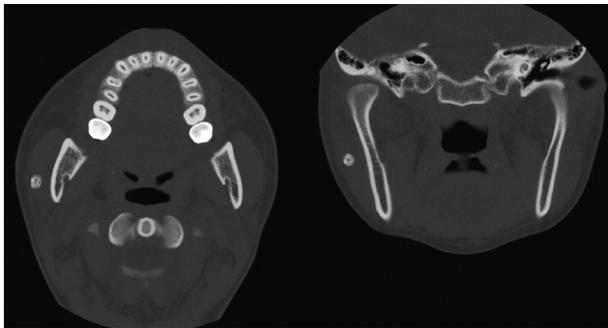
CT image showing a round hard tissue mass approximately 1 cm in diameter in masseteric space (Case I).
